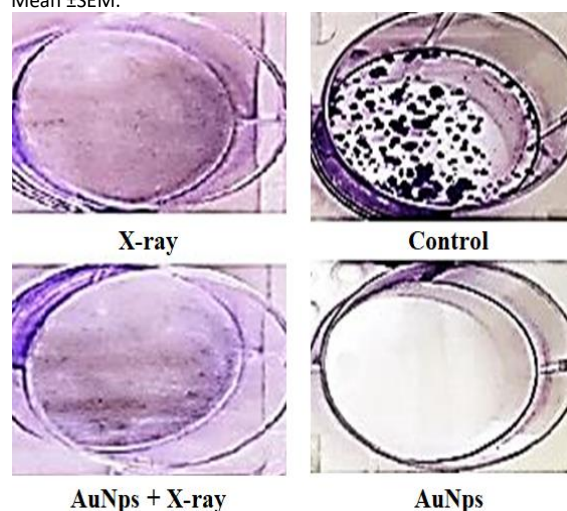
Effect of AuNP, X-ray & their combined treatments on colony formation of MDA-MB-231 cells. Analysis of clonogenic assay revealed a significant reduction in colony formation, indicating the potent anti-clonogenic effects of the treatments.
